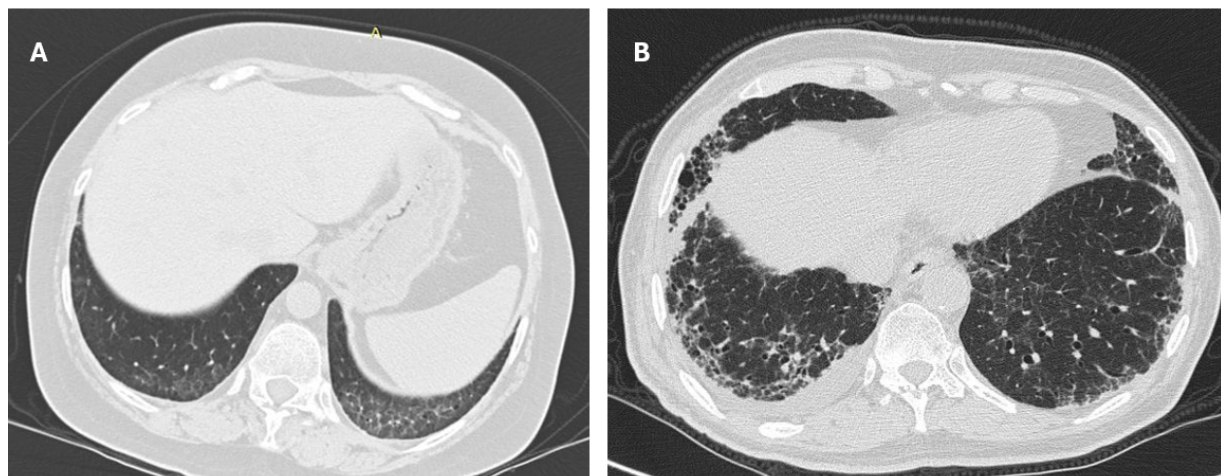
CT images of two patients with rheumatoid arthritis-associated interstitial lung disease. (A) Axial CT image of a 55-year-old male patient shows bilateral subpleural reticular opacities, honeycombing with peripheral and lower lobe predominance, consistent with a usual interstitial pneumonia pattern. (B) Axial CT image of a 49-year-old female patient shows bilateral subpleural ground-glass opacities, more prominent on the left, consistent with a non-specific interstitial pneumonia pattern.
